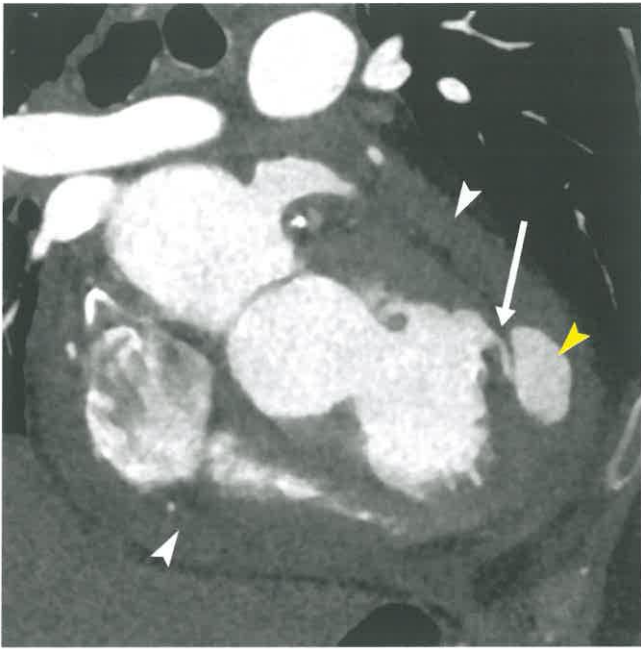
Retrospectively Gated Coronary CTA in a 61-Year-Old Man With Recent LAD Territory Infarct. Coronal oblique reformat shows the narrow-necked tear through the left ventricular myocardium (*white arrow*) with distal pseudoaneurysm (*yellow arrowhead*) and surrounding hemopericardium (*white arrowheads*). Pseudoaneurysm formation represents a myocardial rupture contained by surrounding pericardium or scarring. Although most common in the inferior segments, they can occur anteriorly as well.
